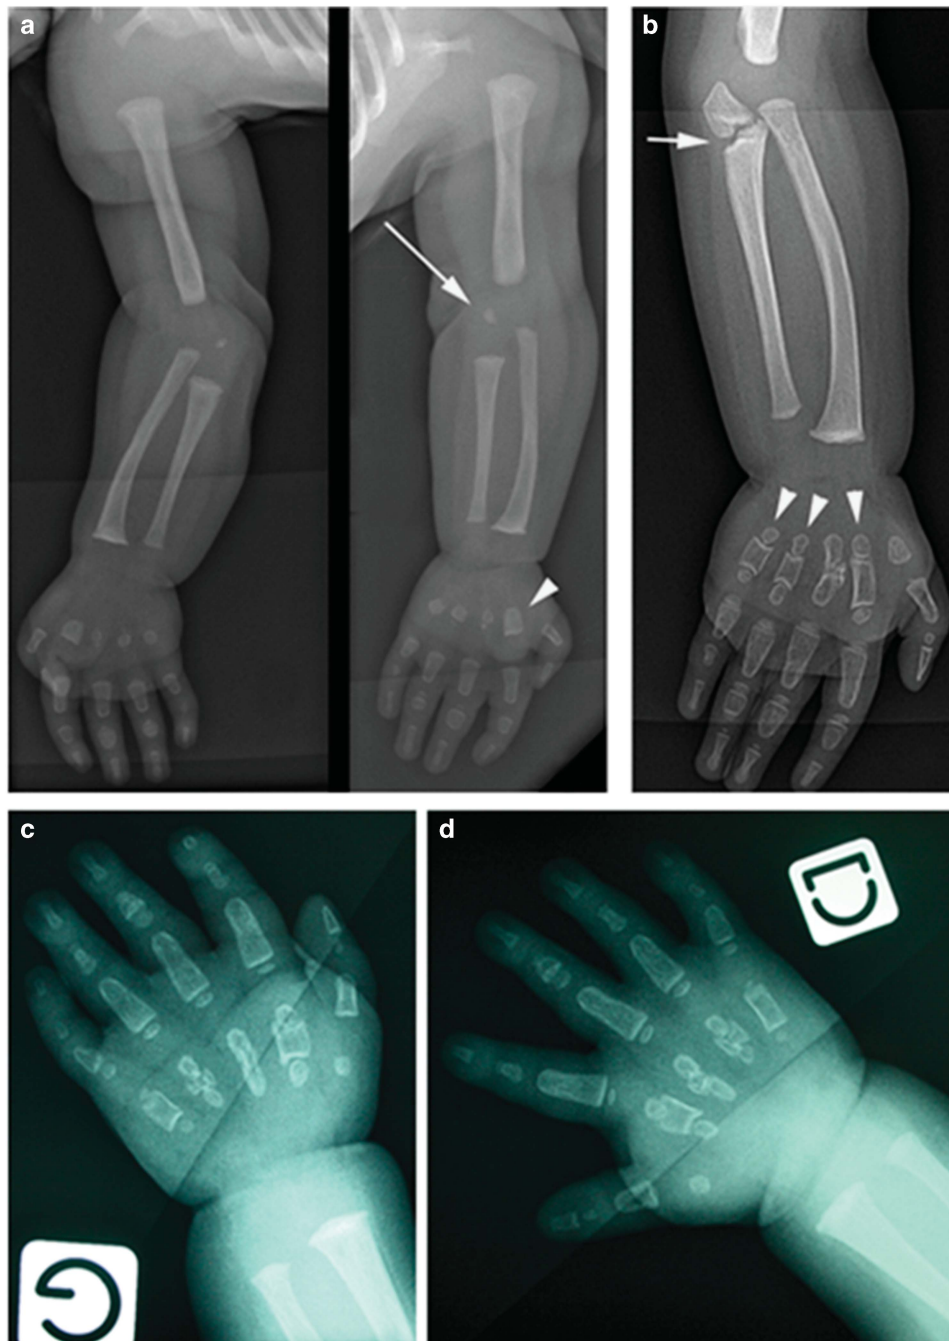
Radiographs of patient 1 and sister. (a) At birth: note shortened humerus, slight bowing of radius, and short ulna with an accessory ossification center at the proximal part. Hands: short and irregular metacarpals, short and broad second to fifth middle phalanges. (b) Forearm and hand at 19 months: aspect of 'pseudarthrosis' at the proximal third of the ulna (arrow), short metacarpals with accessory ossification center (arrowheads), and shortness of middle phalanges, tapering of distal phalanges. Abnormal epiphyseal maturation of metacarpals and phalanges, delayed ossification of carpal bones. (c, d) Hands of the similarly affected sister of patient 1 at age 8 months. Note marked hypoplasia of misshaped metacarpals with accessory ossifications centers at their proximal ends, the shortness of the middle phalanges, disturbed pattern of carpal and epiphyseal maturation with nonossified carpal bones, as well as radial and ulnar epiphyses and – in contrast – advanced and abnormal maturation of metacarpal and phalangeal epiphyses.
